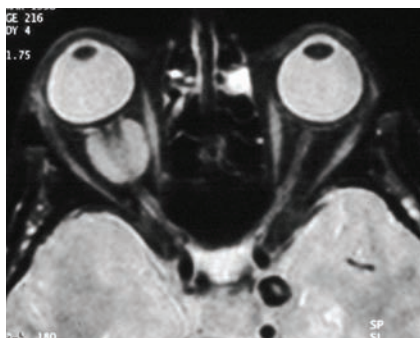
An axial CT scan through the orbits at the level of the optic nerves demonstrating an optic nerve sheath meningioma encasing the right optic nerve. In this case it was responsible for gaze evoked transient visual loss.
